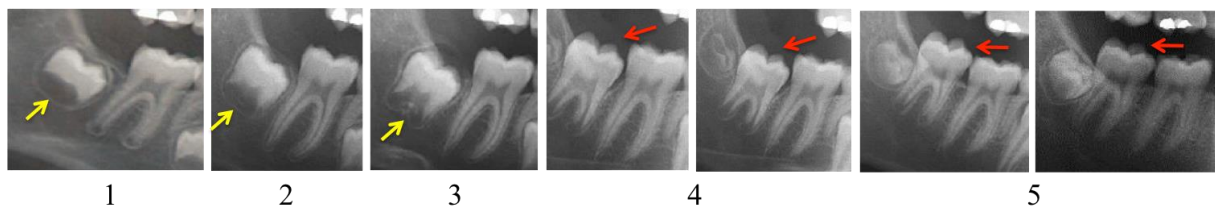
Panoramic radiographies evidencing the second lower molar eruption process according to Marks and Schroeder's classification (1996). Yellow arrows: 1. Pre-eruptive movement; 2. Intraosseous eruption movement; 3. Transmucosal eruption movement. Red arrows: 4. Pre-occlusal eruption movement; 5. Post-eruptive movement.
